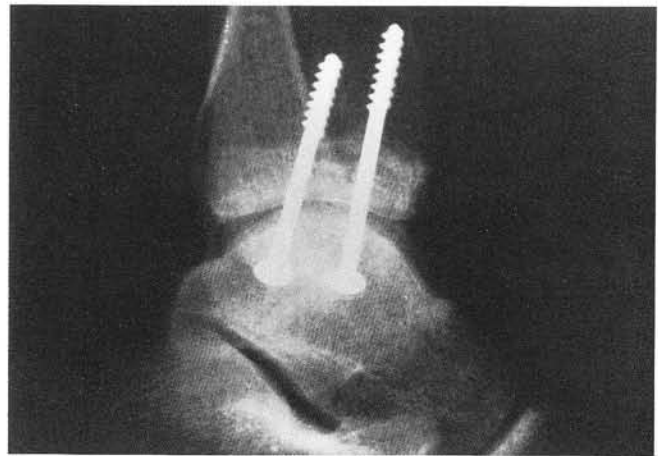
Lateral radiograph.
